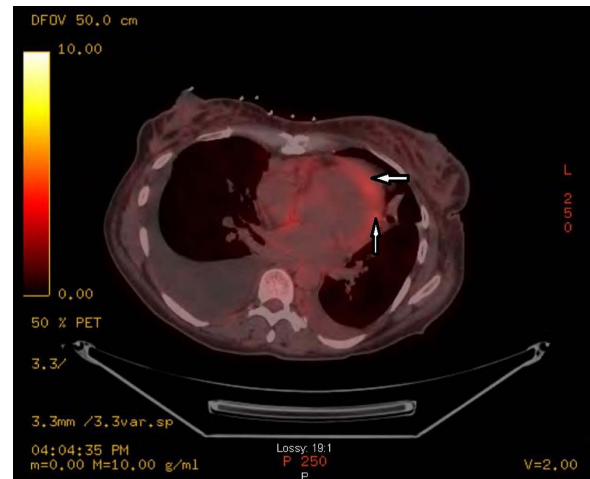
Positron emission tomography-CT scan showing a hypermetabolic pericardial mass consistent with metastatic disease (arrows).
